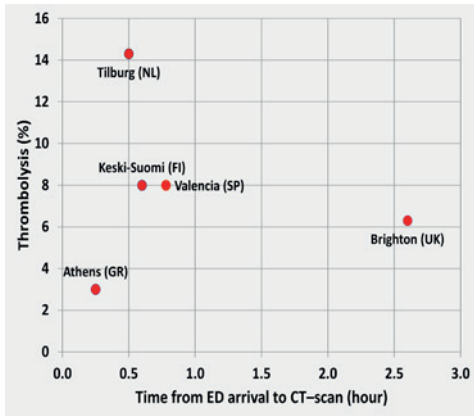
Relationship between ED door-CT scan time and rate of thrombolysis
